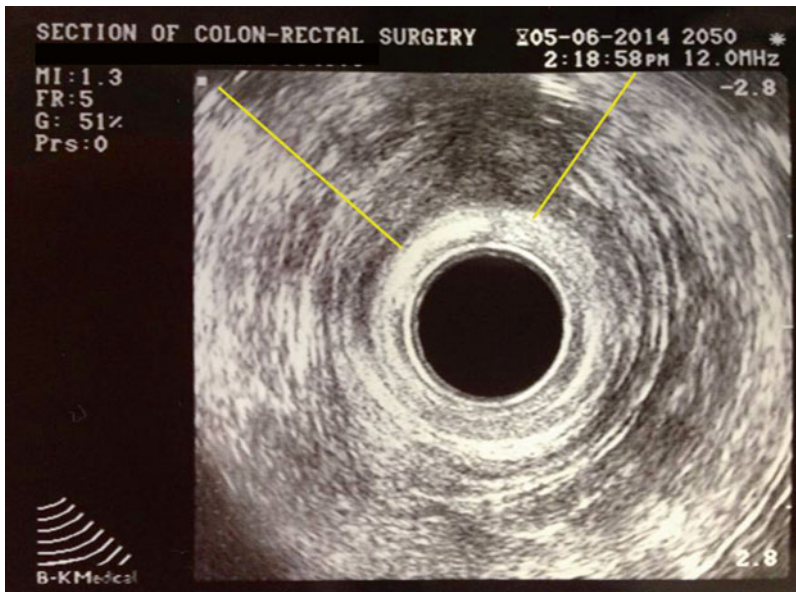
Endorectal ultrasound demonstrating an external sphincter defect
